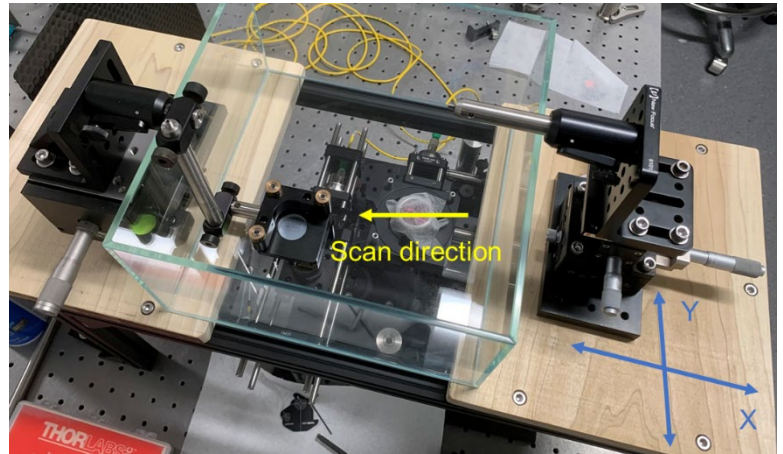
picture of the revised sample arm and reference arm configuration based around the use of a piezoelectric ultrasound transducer with a cylindrical geometry.
